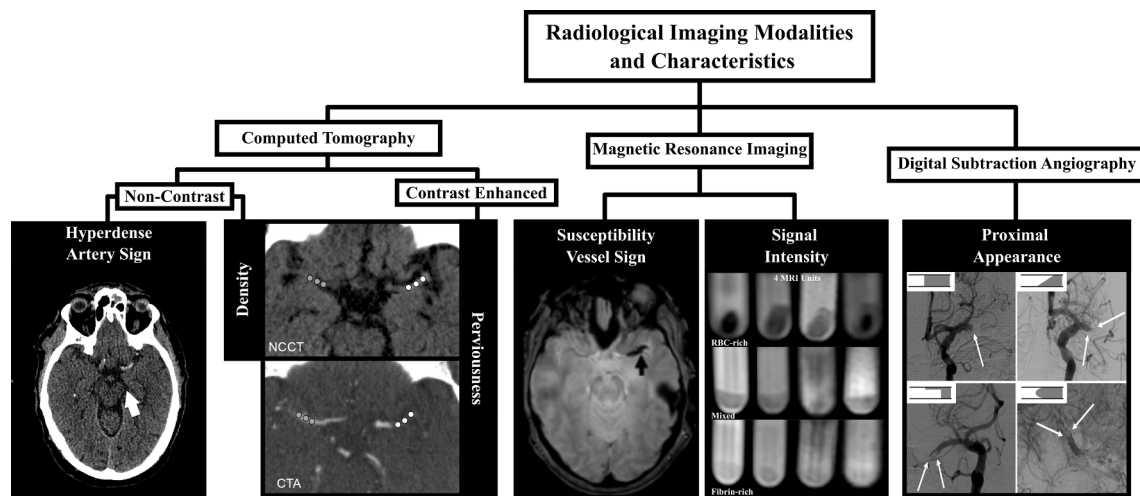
Overview of radiological imaging modalities and characteristics used in the setting of acute ischemic stroke. Computed tomography: hyperdense artery sign, density and perviousness. Magnetic resonance imaging: susceptibility vessel sign (Darcourt et al., International Journal of Stroke (16, 8) pp: 972-980, Copyright © 2021 by World Stroke Organization, modified by permission of SAGE Publications) and signal intensity (Bourcier et al., Journal of Neuroimaging (27, 6) pp: 577-582, Copyright © 2021 by John Wiley & Sons, Inc., modified by permission of John Wiley and Sons). Digital subtraction angiography: proximal thrombus appearance (adapted by permission from Springer Nature: Springer Clinical Neuroradiology (Angiographic Baseline Proximal Thrombus Appearance of M1/M2 Occlusions in Mechanical Thrombectomy, Mönch), Copyright © (2019)).
